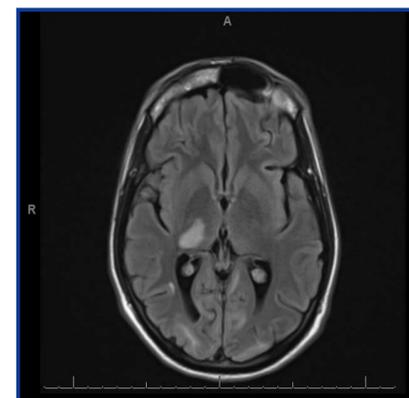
(left): Right thalamic, left frontal and bilateral occipital lesions with high signal intensity on T2/FLAIR
